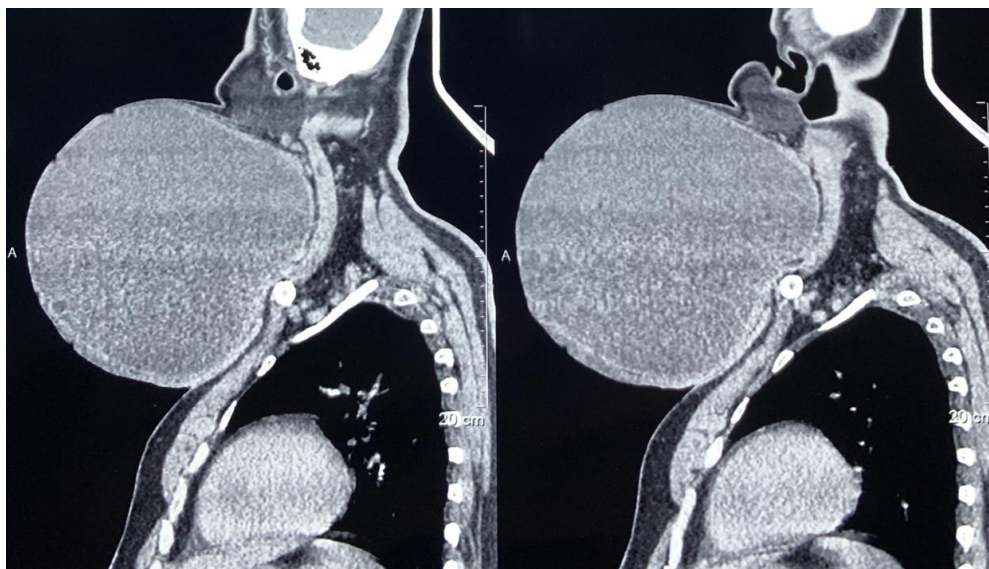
Radiological image: Contrast enhanced CT scan showing an $18 \times 21 \times 19$ cm peripherally enhancing cystic lesion in the left anterolateral neck, displacing the larynx, trachea, and left common carotid artery to the right, and extending to the thoracic inlet, with mild supraglottic airway narrowing (8.3 mm).
